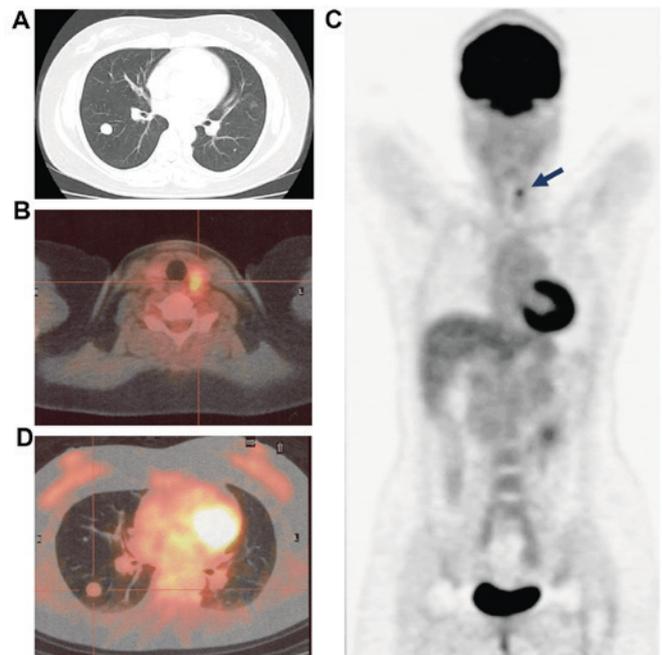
Radiological findings for case 1. (A) CT scan of the pulmonary nodule. (B) A lesion exhibiting high 18-FDG uptake ( $SUV_{max} > 4.9$ ) was detected in the tumor of the left lobe of the thyroid gland (arrow). (C) The fusion image of 18-FDG-PET/CT in the coronal plane. Only one lesion in the thyroid gland exhibited a positive accumulation of 18-FDG (arrow). (D) The fusion image of 18-FDG-PET/CT in the horizontal plane. The pulmonary nodule demonstrated no significant 18-FDG uptake ( $SUV_{max} < 1.6$ ). CT, computed tomography; 18-FDG-PET/CT, 2-deoxy-2-(fluorine-18)-fluoro-D-glucose positron emission tomography/CT;  $SUV_{max}$ , maximum standard uptake value.
